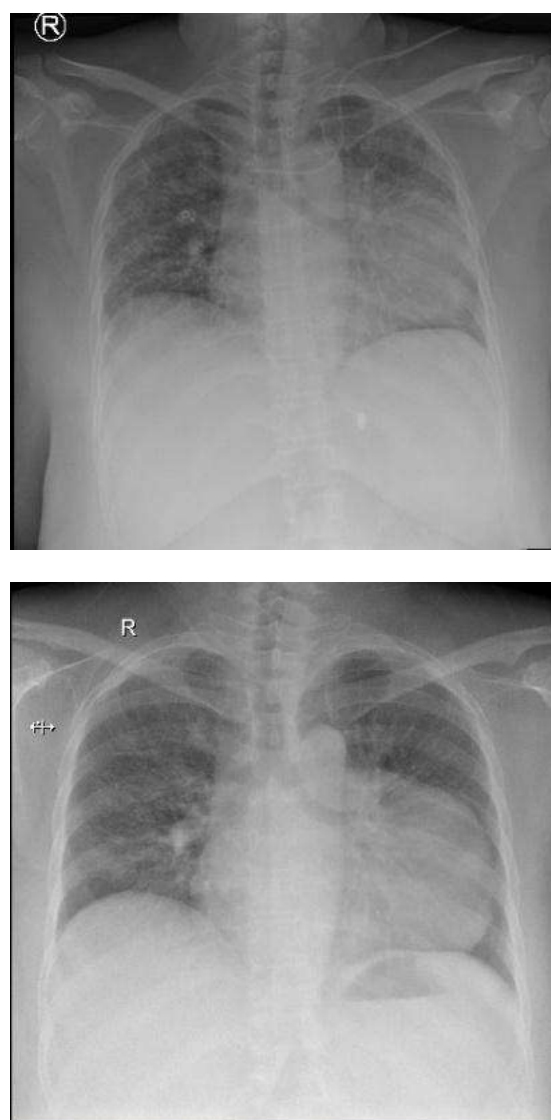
Chest radiograph 2021 (top) and 2022 (bottom)
